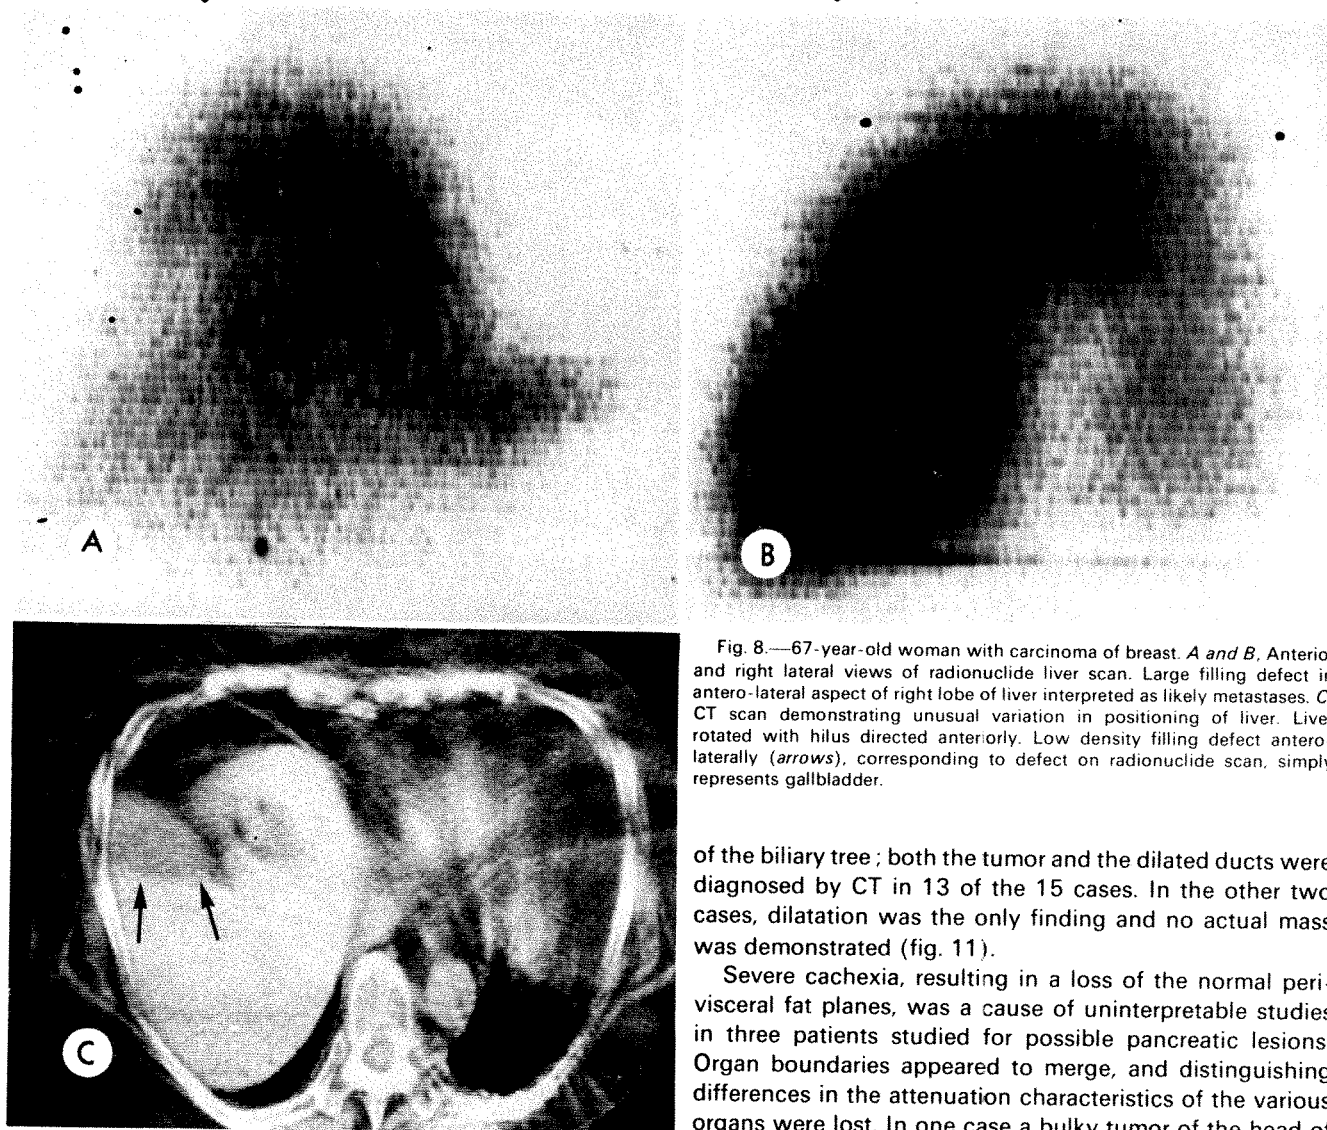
67-year-old woman with carcinoma of breast. *A and B*, Anterior and right lateral views of radionuclide liver scan. Large filling defect in antero-lateral aspect of right lobe of liver interpreted as likely metastases. *C*, CT scan demonstrating unusual variation in positioning of liver. Liver rotated with hilus directed anteriorly. Low density filling defect antero-laterally (*arrows*), corresponding to defect on radionuclide scan, simply represents gallbladder.
